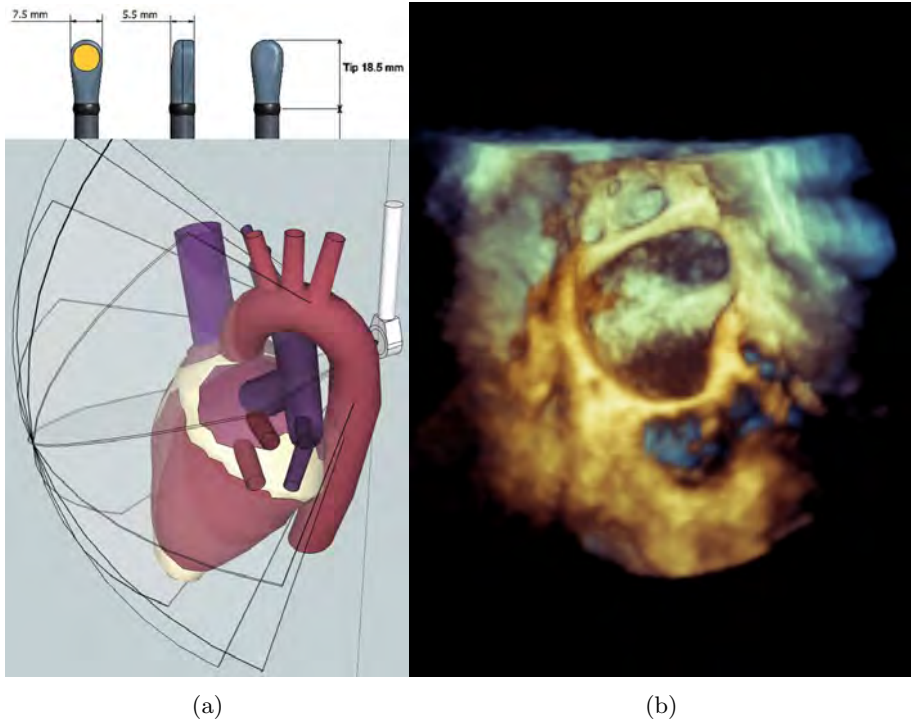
1.3a, Dimension of the μ TEE probe tip (courtesy of Oldelft Ultrasound, Netherlands) and the conical volume that can be scanned by rotating the 2D image plane by 180 degrees. 1.3b: An example 3D rendering of a 3D TEE probe. The anatomy of the left atrium with the mitral valve, atrial appendage, and the left pulmonary veins are visible.
